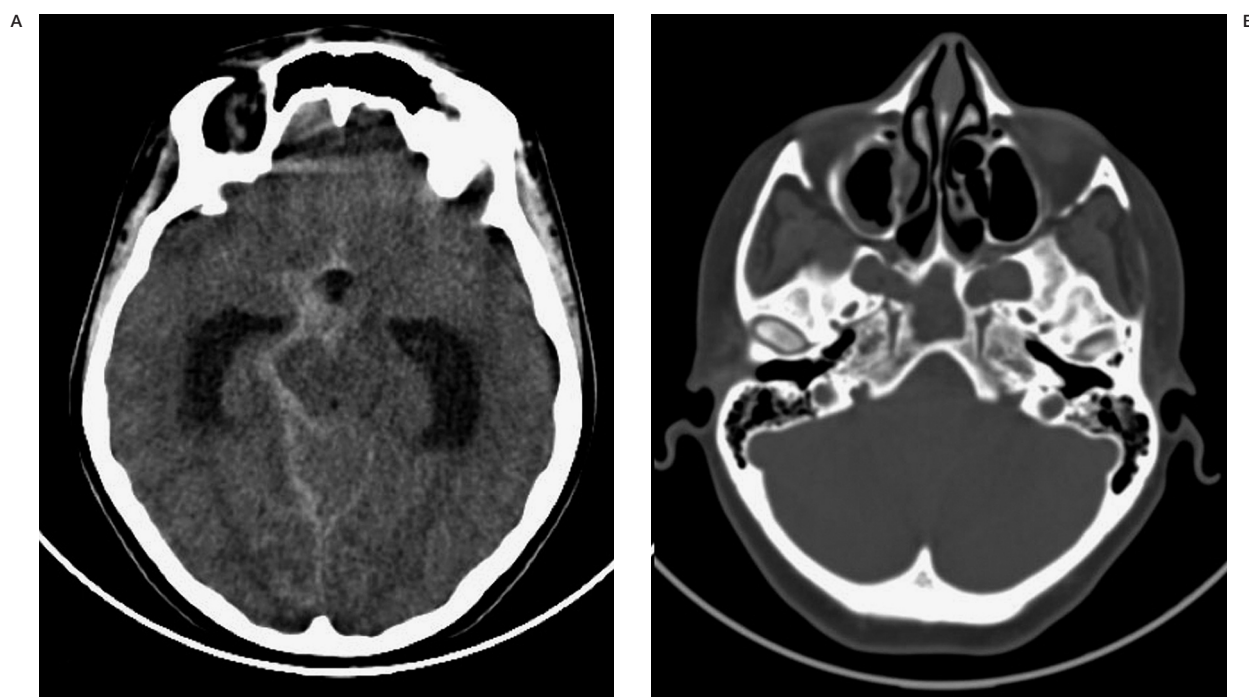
Unenhanced Axial CT shows a diffuse SAH, which is denser in the right perimesencephalic cisterns. Axial CT of the skull base bone window demonstrates the absence of the bilateral carotid canal.
